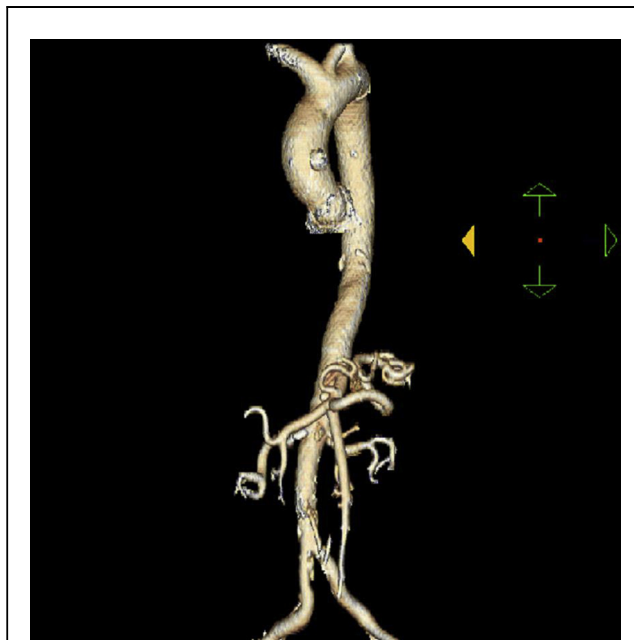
Post-Procedure CT
